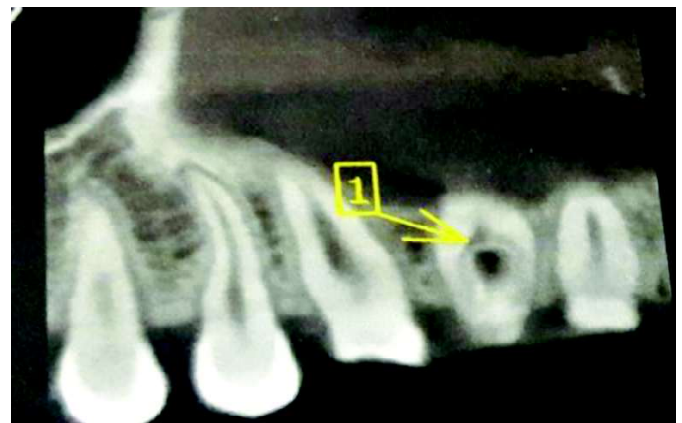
CBCT image showing central anomalous structure surrounded by pulp
